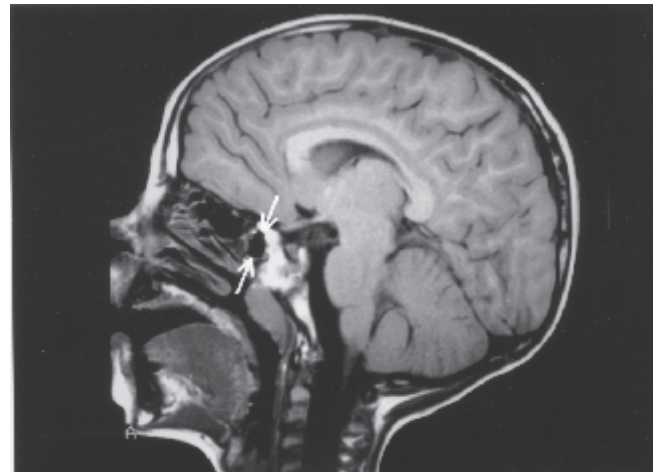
Midsagittal T1-weighted MR-image (650/30) in a 16-month old girl demonstrates onset of pneumatization of the anterior part of the sphenoid bone (arrows).
